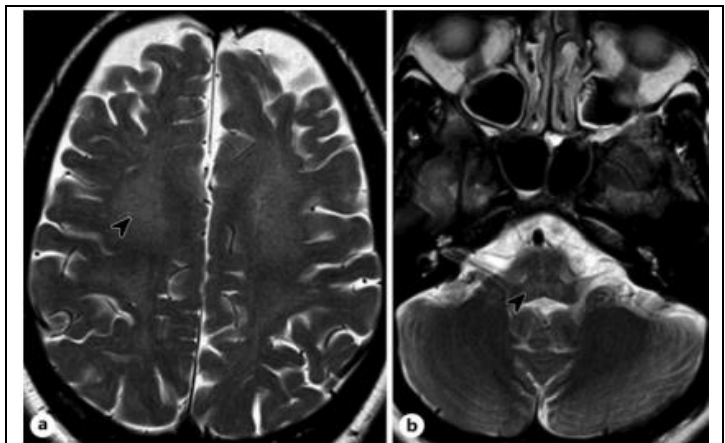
Axial T2w brain MRI images show frontal lobe cortical atrophy and diffuse hyperintense lesions in semiovale and periventricular areas (a), as well as in the pons without cerebellar atrophy (b).
